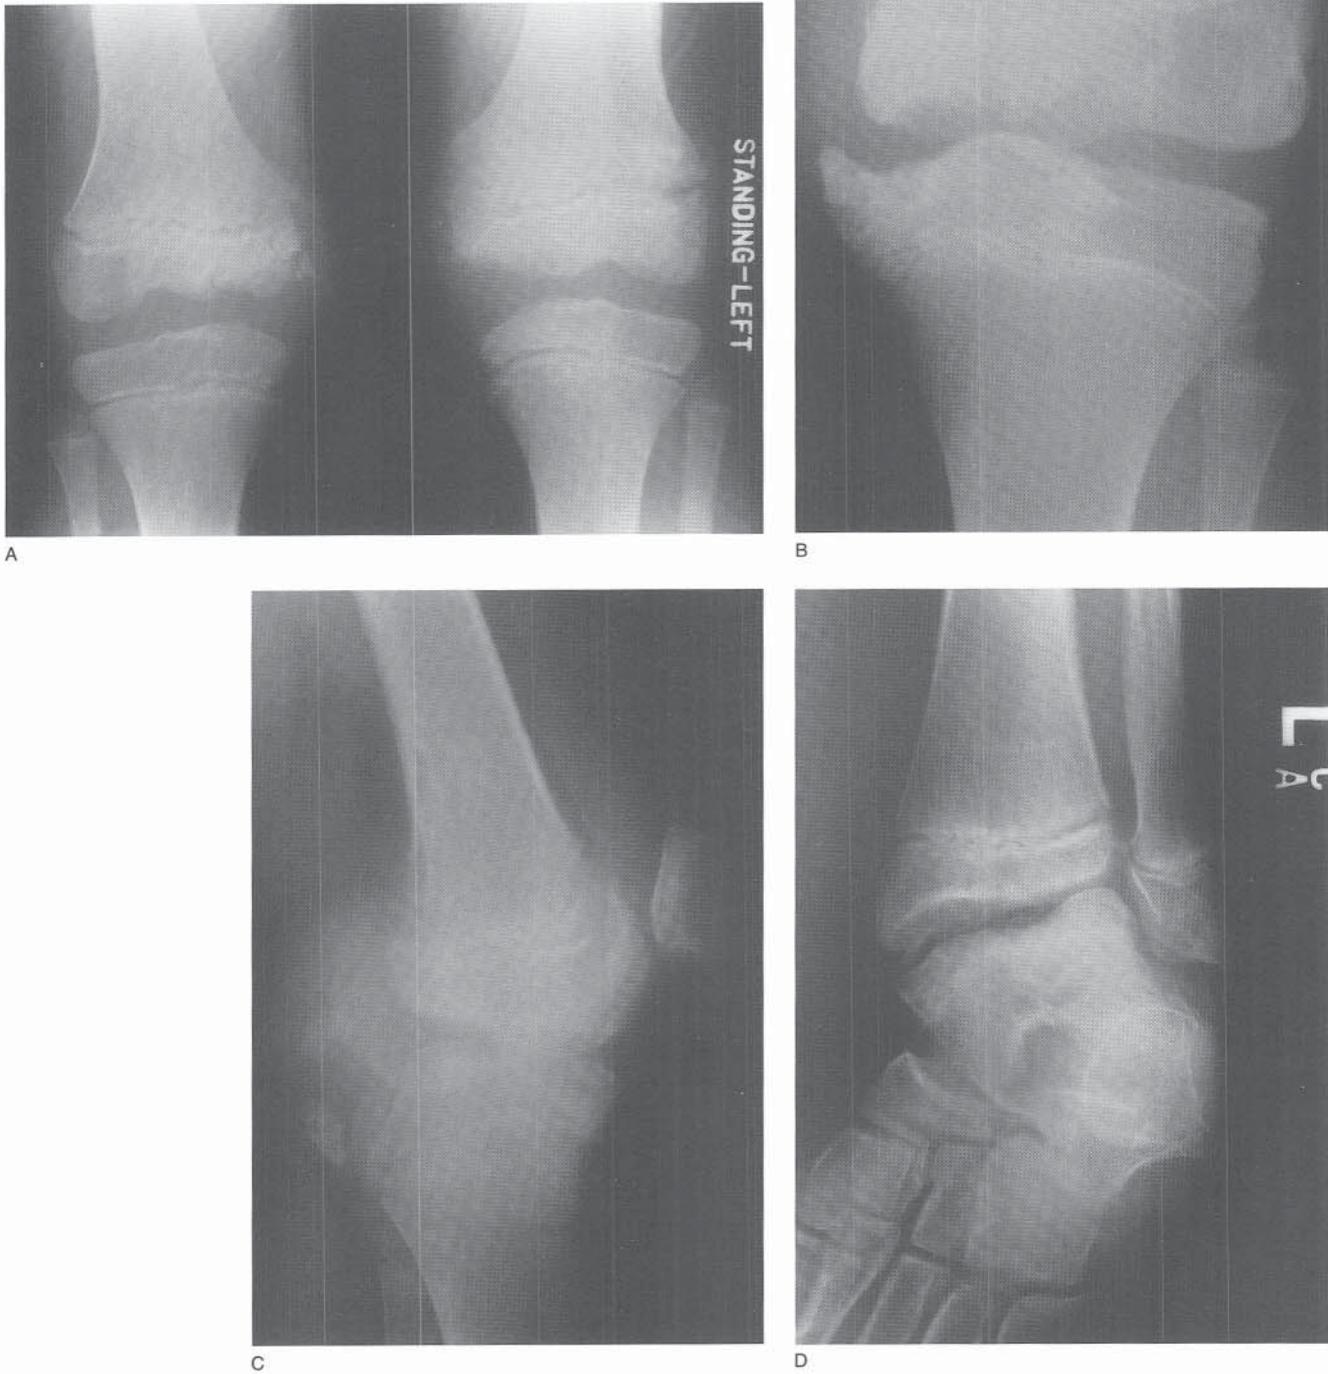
A, Charcot knees in an 8-year-old boy with congenital indifference to pain. B and C, AP and lateral radiographs obtained at age 16 show destruction of joint with multiple loose bodies. D, Charcot changes at the ankle are also present at age 16.
